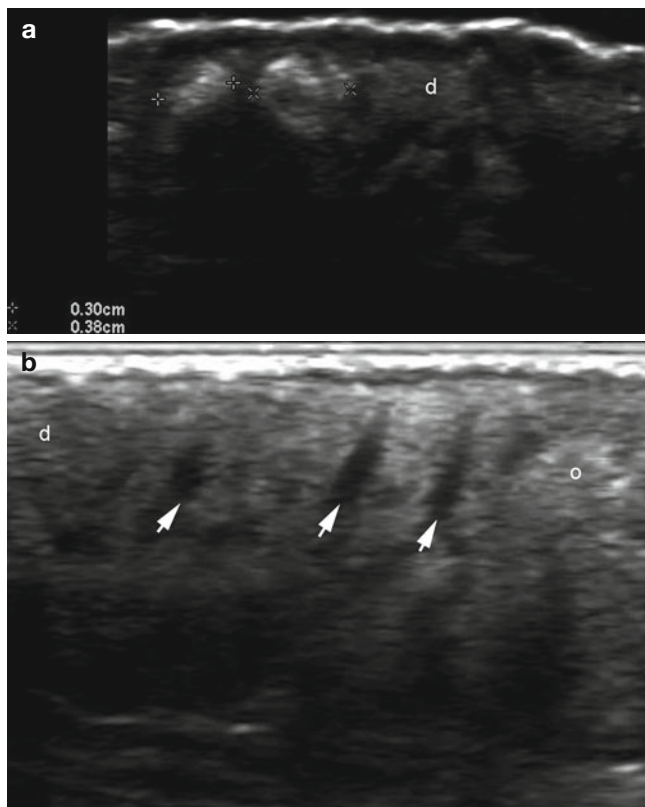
(a, b) Folliculotropic mycosis fungoides. (a, b) Grey scale ultrasound images (occipital region of the scalp (a transverse; b longitudinal view). (a) Ultrasound image demonstrates hyperechoic deposits (between markers) surrounding the dermal hair follicles. (b) Ultrasound image shows thickening of the dermal hair follicles (arrows) and some hyperechoic deposits (o). Abbreviation: d dermis
